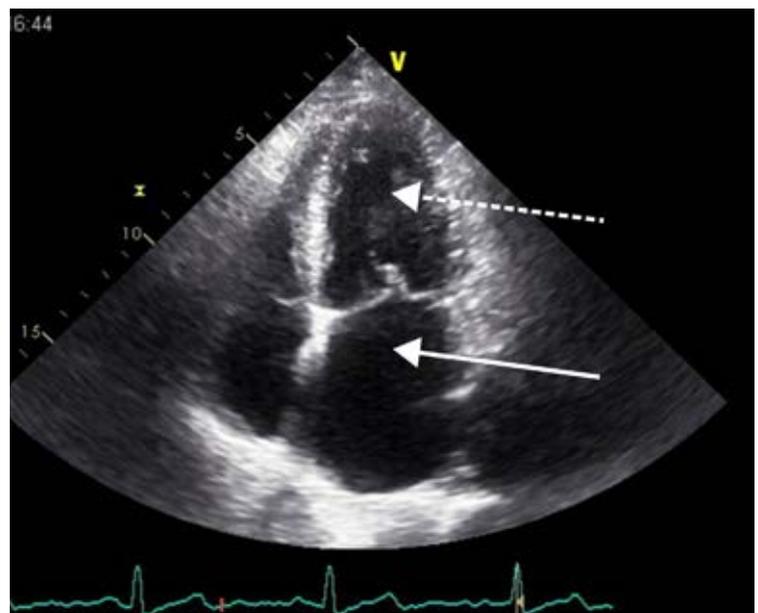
Echocardiogram of an elderly man with breathlessness. Diagnosis of heart failure with normal ejection fraction was made based on the combination of symptoms, a raised concentration of N-terminal B-type natriuretic peptide, and a dilated left atrium (white arrow). Note that the left atrium is a similar size to the left ventricle (broken arrow). Left ventricular ejection fraction was 62%
